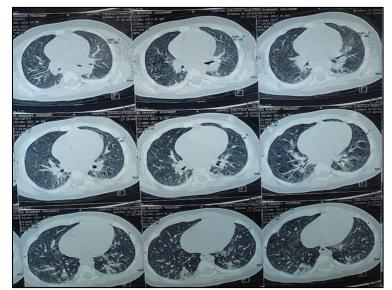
Thoracic CT Scan in Transverse Sections Showing Alveolar Condensations of the Ventral Segment of the Right Upper Lobe and Left Internal Basal Lobe, Initially Suggesting an Infectious Origin.
